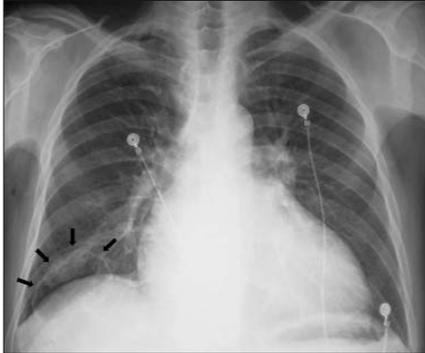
Chest radiography image showing increased cardio-thoracic ratio and the cavitary mass in the right lower lobe (black arrows)
